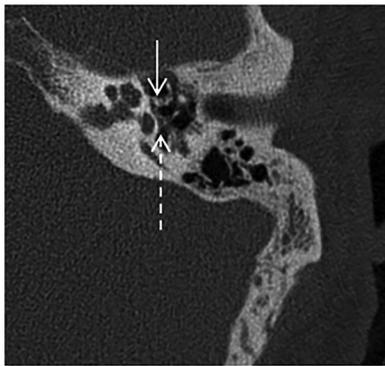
Congenital malleus dysplasia and ossicular fixation. Axial CT demonstrates flattened and small malleus head consistent with hypoplasia. Compare Fig. 3 for normal appearance of the malleus head. There is also congenital fixation to the lateral epitympanic wall.
